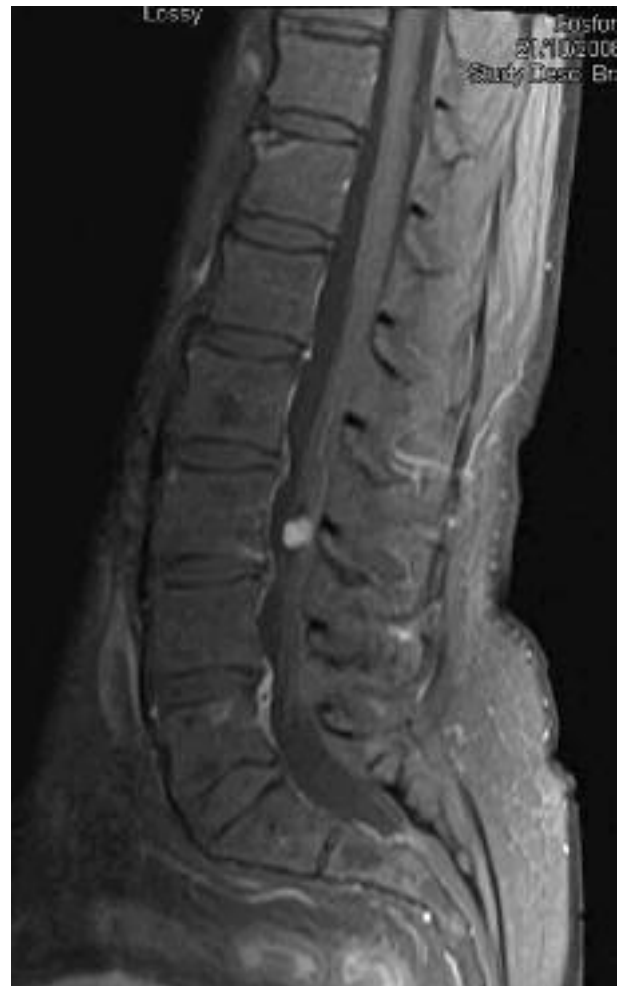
T1 weighted gadolinium-enhanced sagittal MRI of the lumbar spine showing avid homogeneous enhancement of the lesion. This should raise the suspicion of a possible vascular tumor.
